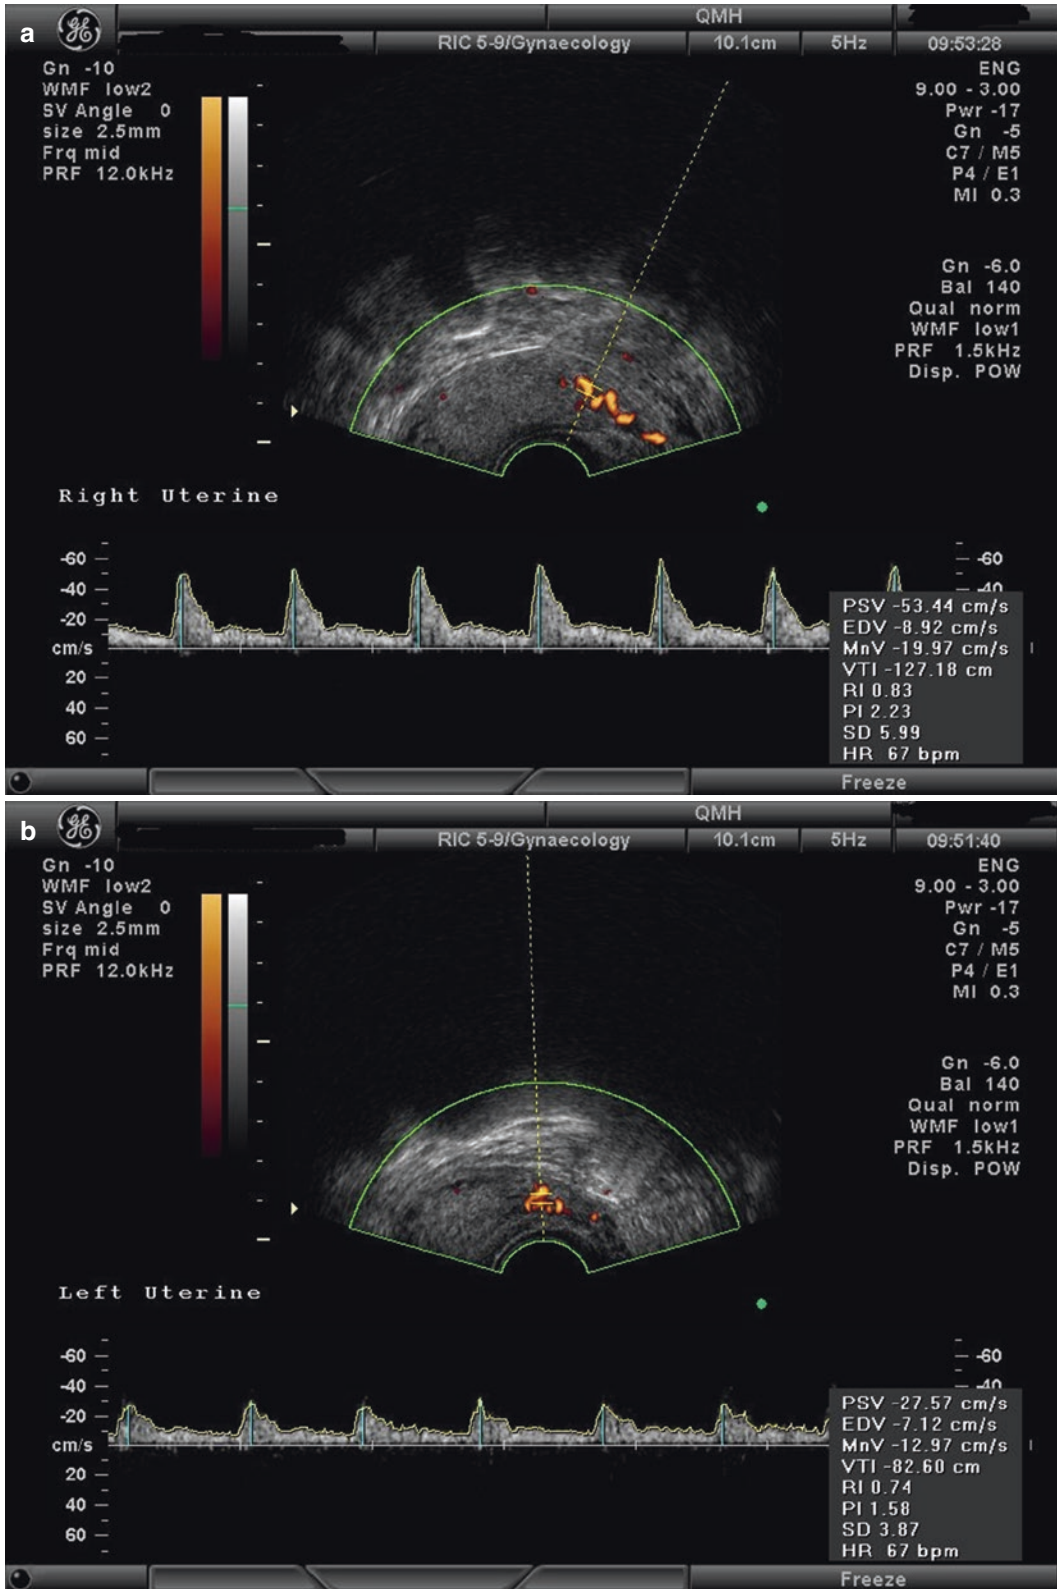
(a, b) Uterine blood flow measured by 2D Doppler ultrasound
